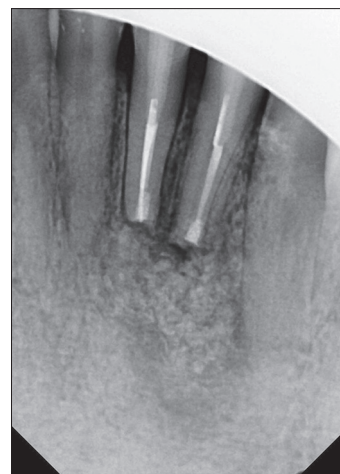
periapical radiograph at 3 months postsurgery
